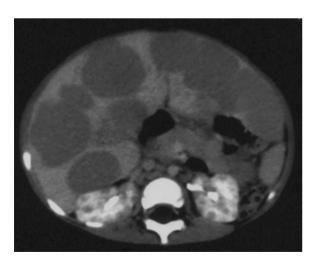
Burkitt's lymphoma in a 2-year-old boy presenting with increasing abdominal volume. Enhanced CT scan shows multiple low attenuating cortical nodules together with large liver locations
